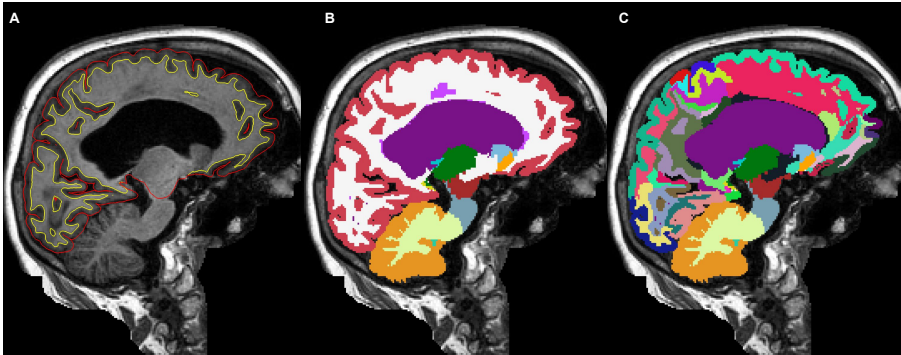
Sagittal slices (defaced) from MRI of a patient from [159] displaying the pial (red) and white matter (yellow) surfaces (A), brain segmentation (B) and white matter refined segmentation (C) obtained with FreeSurfer [52]. Coloring indicates different anatomically defined subregions.
